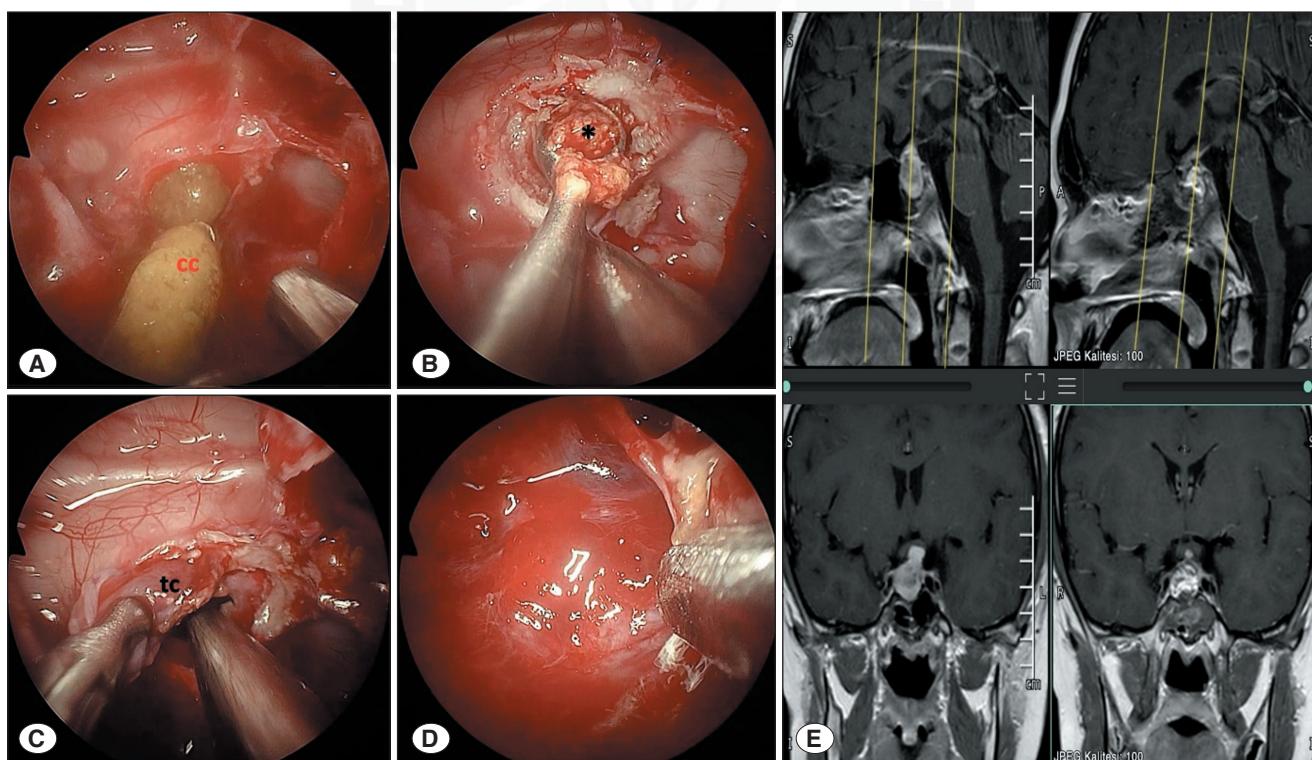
A 13-year-old patient presenting with headache. A) Intraoperative view during endoscopic endonasal surgery showing aspiration of yellowish cystic content following sellar puncture. B) Removal of calcified components of the lesion using a curette. C) Dissection of the cyst capsule and excision using a punch. D) Visualization of the intrasellar space after complete tumor removal. E) Preoperative and postoperative MR images demonstrating gross total resection of the lesion.
